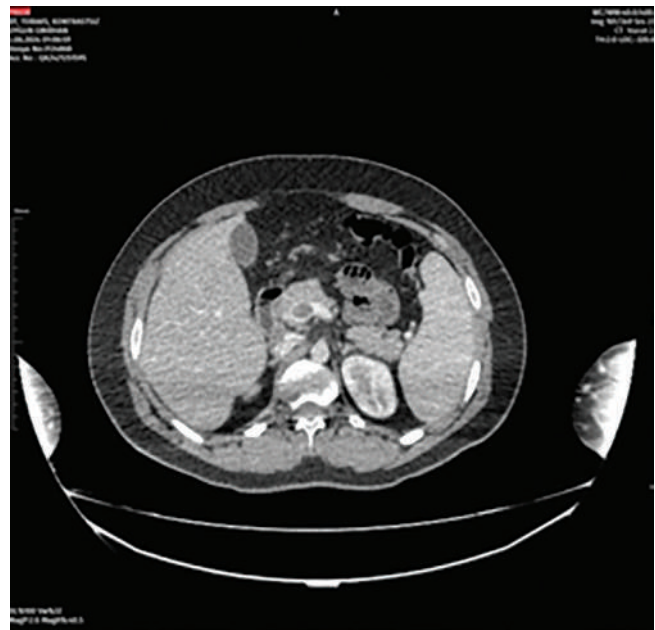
Contrast-enhanced abdominal CT showing superior mesenteric vein thrombosis (axial).
